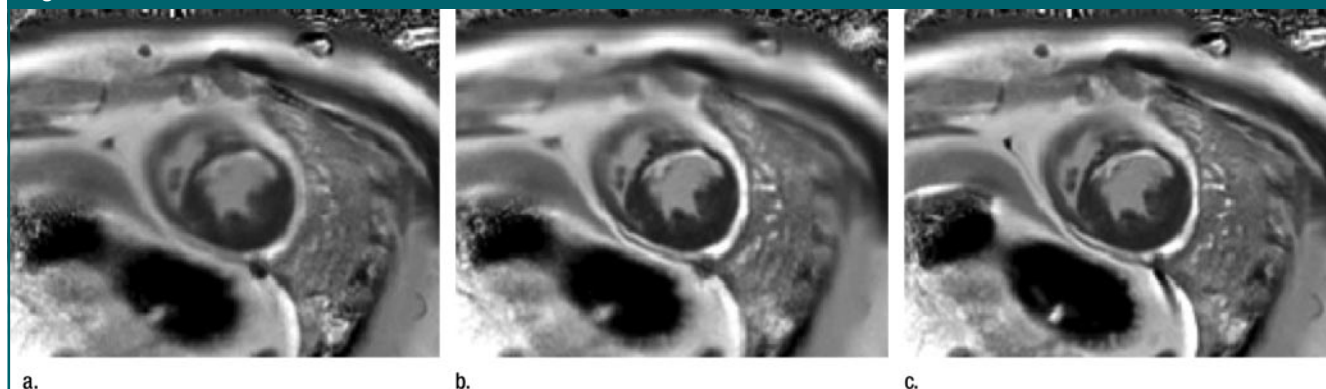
Delayed gadolinium-enhanced MR images in patient with chronic myocardial infarction. Images were acquired during free breathing and averaged over 30 frames with (a) no motion correction, (b) rigid body motion correction derived by registering user-defined region around LV in each image to same region in one frame used as reference, and (c) nonrigid motion correction derived by using automatic full field-of-view registration. (Adapted and reprinted, with permission, from reference 164.)
